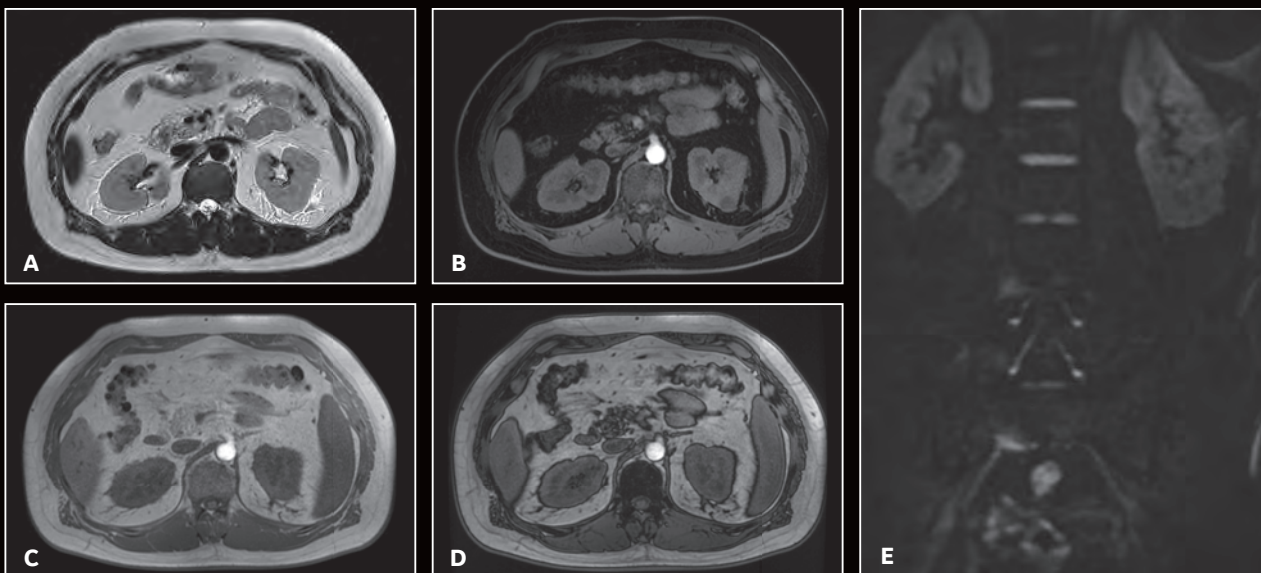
Patient weighed over 200 lbs. (120 kg). Abdominal kidney exam using the AIR Technology™ AA required a wide FOV, however, highly uniform images were acquired. (A) Axial T2w PROPELLER MB, 0.8 x 0.8 x 5 mm, ASSET 4.0, 5:39 min.; (B-D) Axial LAVA Flex; (B) water; (C) in-phase; (D) out-of-phase: 1.6 x 1.6 x 4 mm, 14 sec.; and (E) Coronal DWI b900, 3.1 x 1.6 x 5 mm, ASSET 4.0, 4:20 min.
